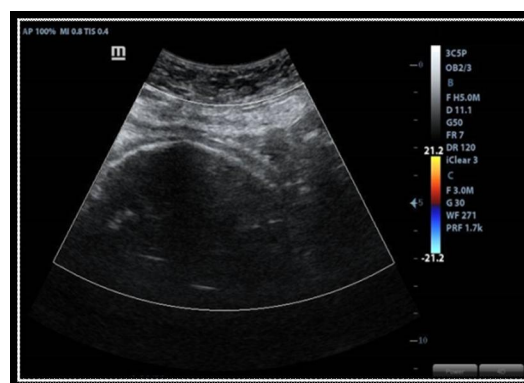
color doppler on lower uterine segment.
